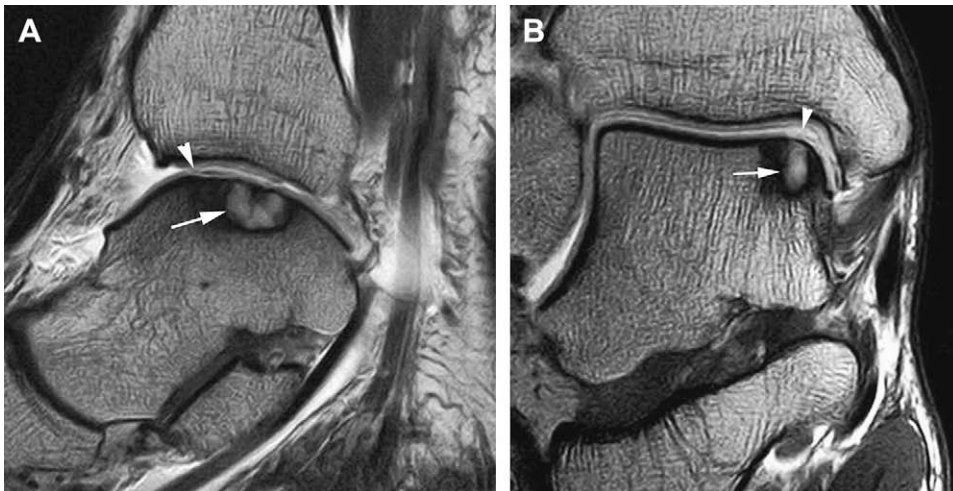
Cystic osteochondral lesion of the talus. (A, B) Sagittal and coronal T1-weighted MR arthrograms of the right ankle demonstrate cystic medial osteochondral lesion of the talus (arrows). Note existence of cartilage detached flap (arrowheads).
